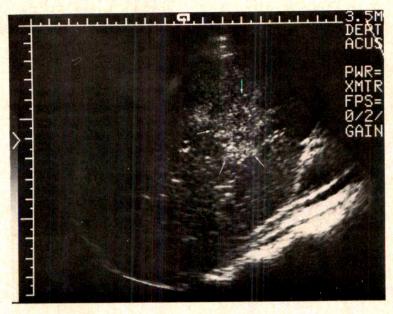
Sonogram of the right lobe of the liver showing the heterogeneous texture of the parenchyma, and a bright echogenic mass (arrows).
